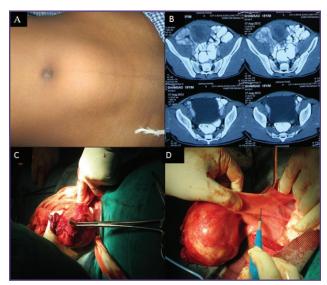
(A) Patient presenting with a lower abdominal mass arising from the pelvis 2 cm below the umbilicus. (B) Computed tomography showed a well circumscribed mass with peripheral solid component and internal septations with areas of myxoid change, hemorrhage and necrosis abutting the dome of the urinary bladder and the anterior abdominal wall, however the fat plane was maintained. (C) & (D) Tumor removed en bloc together with the umbilicus and bladder dome.
